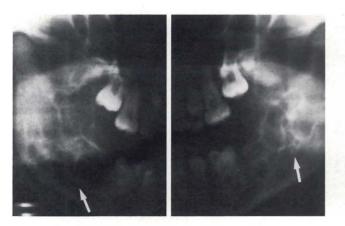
Panoramic radiograph of the twelve-year-old patient, demonstrating bilateral multilocular cystic lesions in the mandible and partial anodontia characteristic of cherubism.
